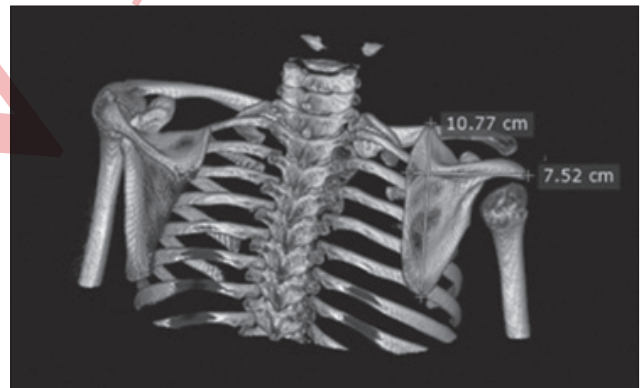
CT scan of a patient with EOP. Measurement of SHEAR deformity (patient O., 9 years old): SHEAR deformity I (2.5 % of scapular standing above the clavicle in the frontal plane of CT).
